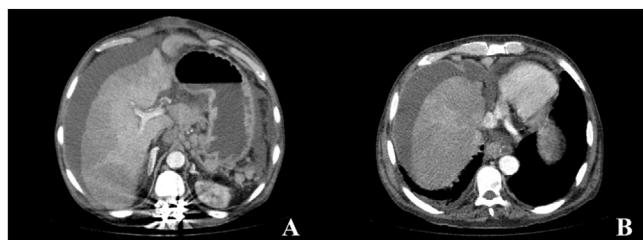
Abdominal CT images with intravenous contrast material in the portal phase, axial MIP reconstruction. (A and B) Signs of chronic liver disease, chronic thrombosis of the suprahepatic veins and inferior vena cava, development of collateral perigastric and perihepatic veins, as well as ascites in all the compartments.
